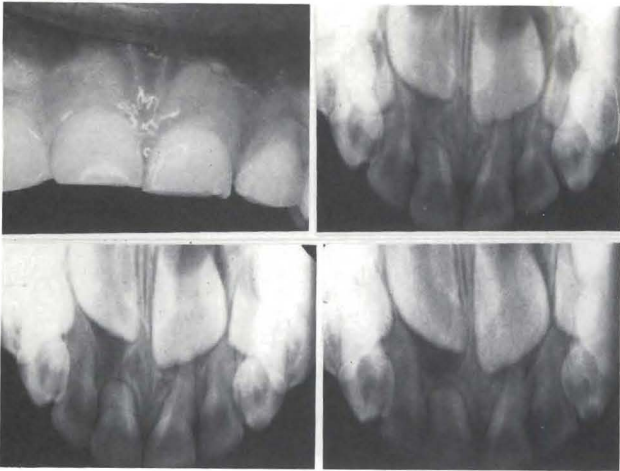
Findings: 5.5-year-old girl struck tooth E at about two years of age. Tooth E was mobile, not sensitive to percussion or palpation; had normal color, and normal associated soft tissues (clinical photograph). Increased PDL space, periapical radiolucency, and external root resorption were seen on the radiograph. The tooth E was extracted approximately forty-two months after trauma.
